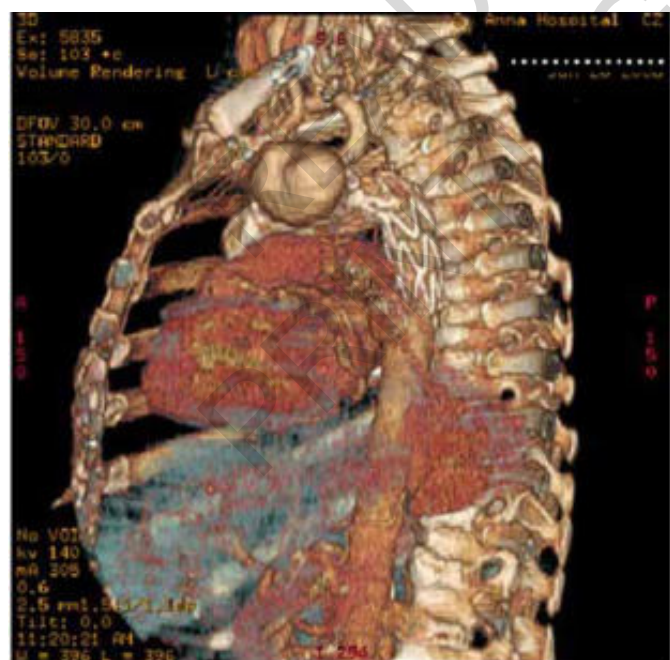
Three-dimensional VR sagittal view. CT image shows the endoprosthesis and the large pseudoaneurysmal sac.
